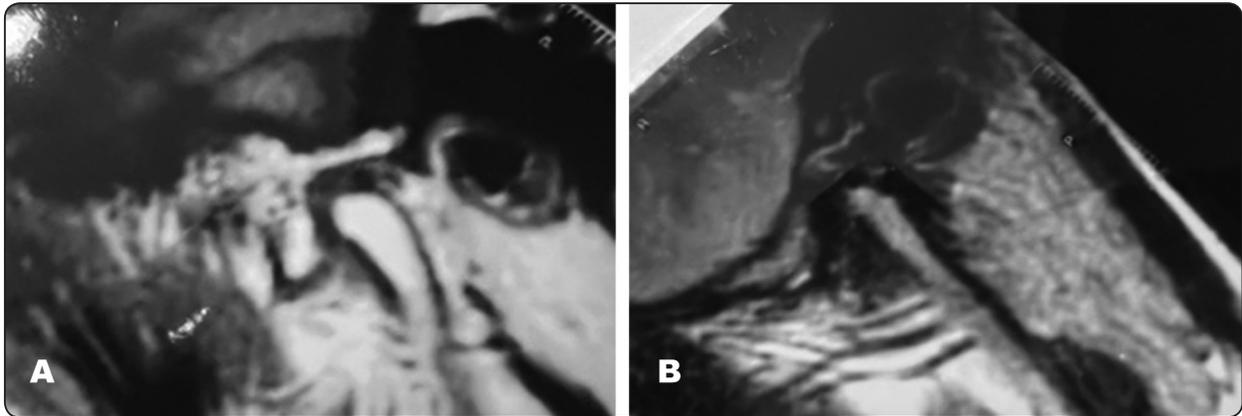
MRI evaluation: A) preoperative anterior meniscal displacement with synovitis and abnormal morphology of retrodiscal tissues B) postoperative MRI show partial eminectomy and proper position and morphology of disc without synovial fluid effusion.
